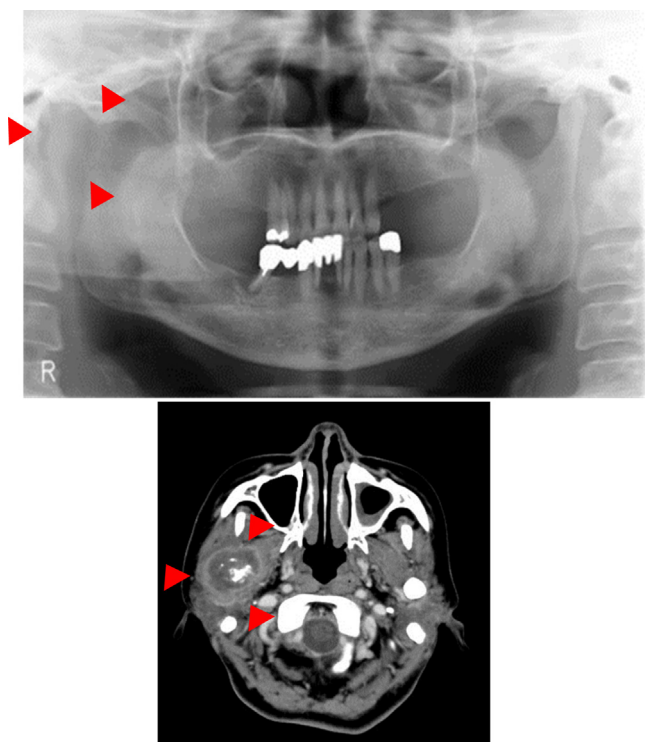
Preoperative X-ray images obtained in June 2008. The findings of panoramic radiography (upper) and computed tomography (lower) revealed an increase in tumor size (indicated by the red arrowheads) with bone destruction. The right mandibular condyle appeared unclear due to the growth of the mass. (For interpretation of the references to color in this figure legend, the reader is referred to the web version of the article.)
